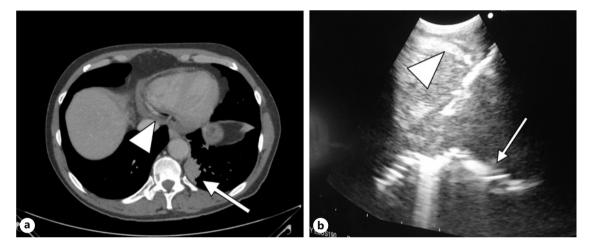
a CT scan with pericardial effusion. The arrow shows suspicious lesion in the left lower lobe. The arrowhead shows fluid in the posterior pericardium. b EUS-B picture of the needle in the pericardial effusion. The arrowhead shows the pericardium, and the arrow shows the myocardium.
